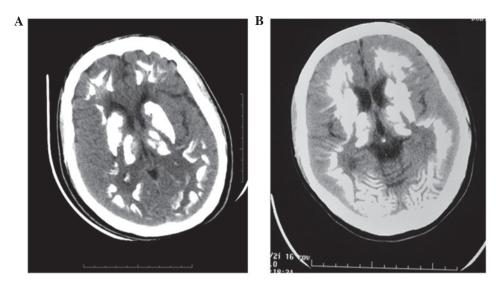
Brain computed tomography images showing calcification in the brains of patients with Fahr's disease. (A) Male patient. (B) Female patient.
